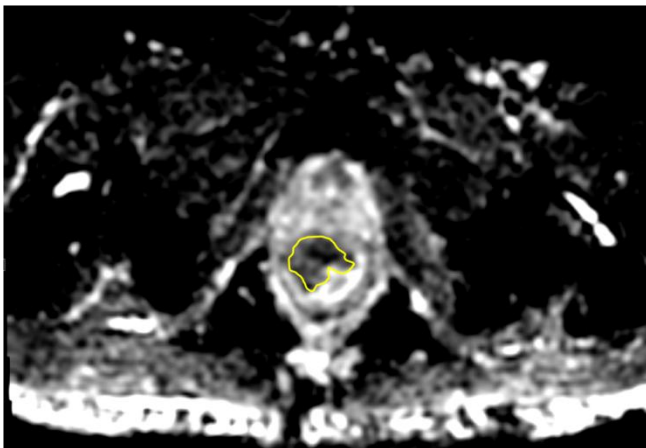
ADC map corresponding to Fig. 10 showing dark areas matching the bright signal on DWI (outlined in yellow) suggestive of restricted diffusion and thereby implying residual disease.
